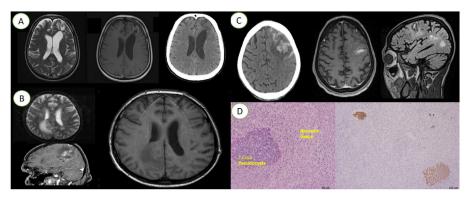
A. From left to the right; cranial magnetic resonance image with dilatation of ventricles and subcortical area of heterogeneous signal in the left frontal region; T_1 sequence, with hyposignal in the same region; cranial computed tomography scan with hypoattenuating left frontal area.
